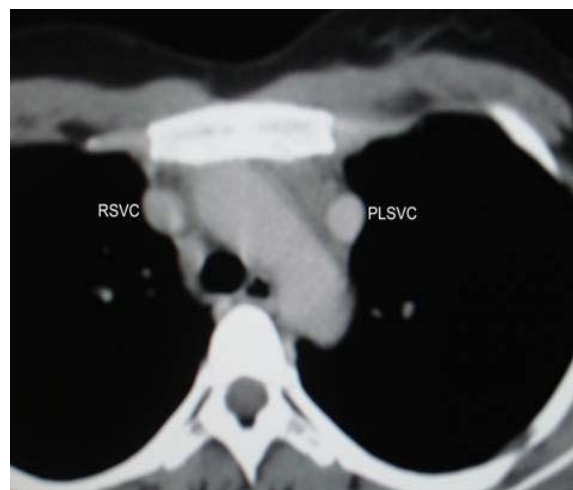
Thoracic computed tomographic scan with contrast showing normal right superior vena cava (RSVC) and the left persistent superior vena cava (PLSVC).
